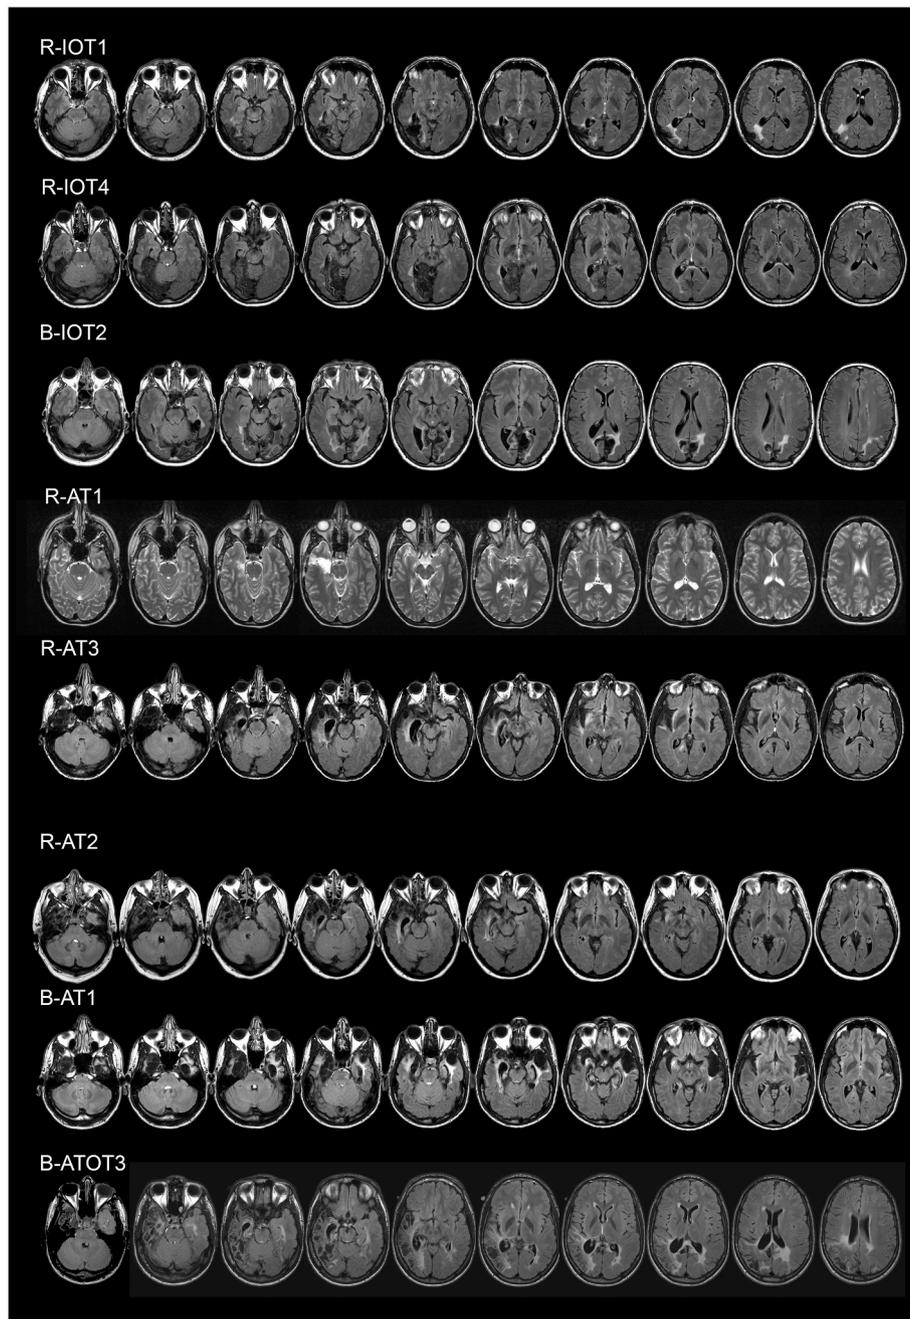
Axial MRI scans for the eight subjects with acquired prosopagnosia. FLAIR images are shown for all except for the T2-weighted image for R-AT1.
